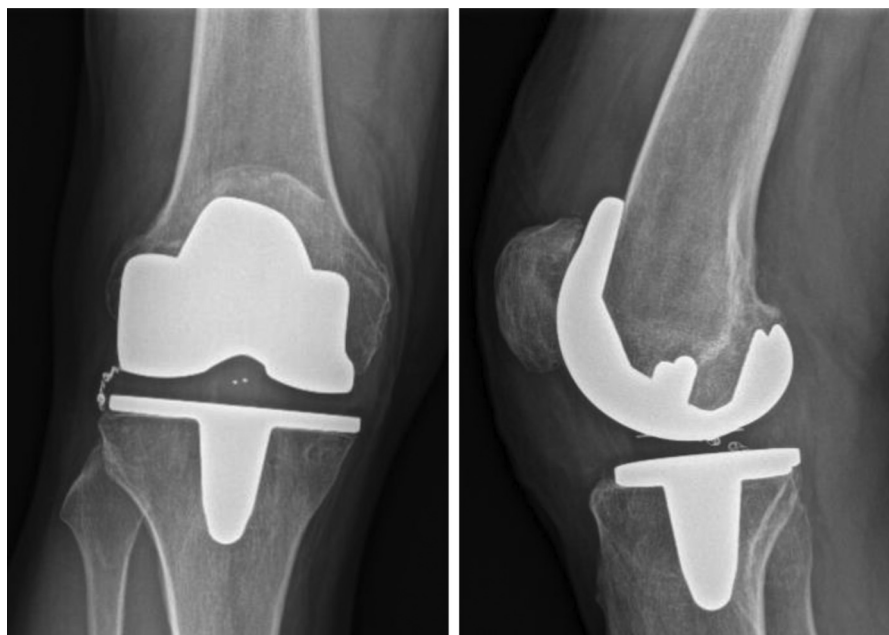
Anteroposterior (left) and lateral (right) radiograph performed 5 years after the operation.
